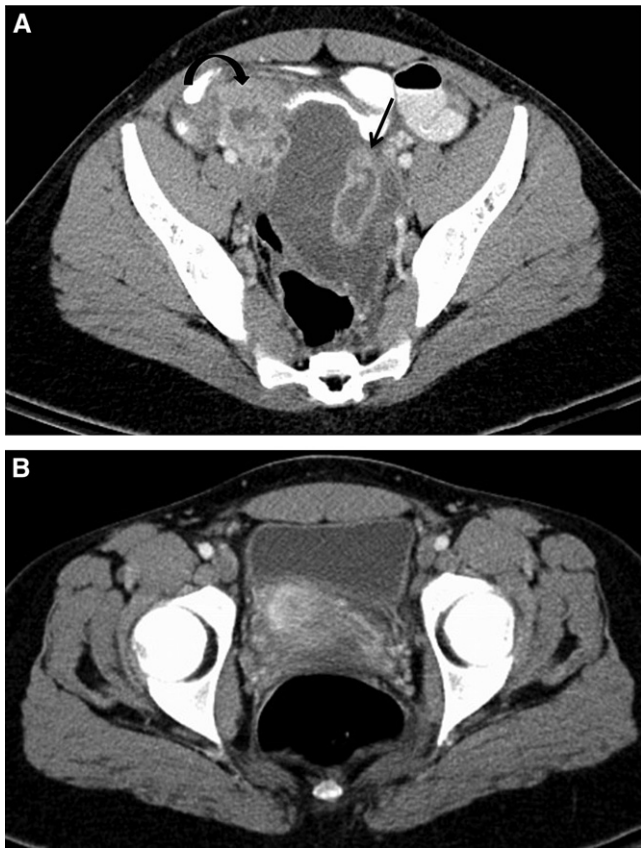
Bilateral tubo-ovarian abscesses/pyosalpinx and associated cervicitis in a 20-year-old patient with left lower quadrant pain, nausea, and vomiting. (A) Axial contrast-enhanced computed tomography (CECT), showing a tubular cystic mass in the left pelvis (black arrow), with a thickened and enhancing wall, which represents a TOA/pyosalpinx, which closely abuts the bladder. The right adnexa has a similar appearance but is larger, with a fluid-filled, tortuous fallopian tube, with a thickened and enhancing wall (curved black arrow), which cannot be separated from the right ovary. (B) Axial CECT, demonstrating a thickened and abnormally enhancing cervix, which represents cervicitis.
